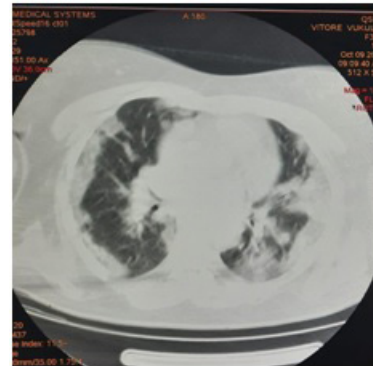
Chest CT scan multifocal ground-glass opacities with partial consolidation
